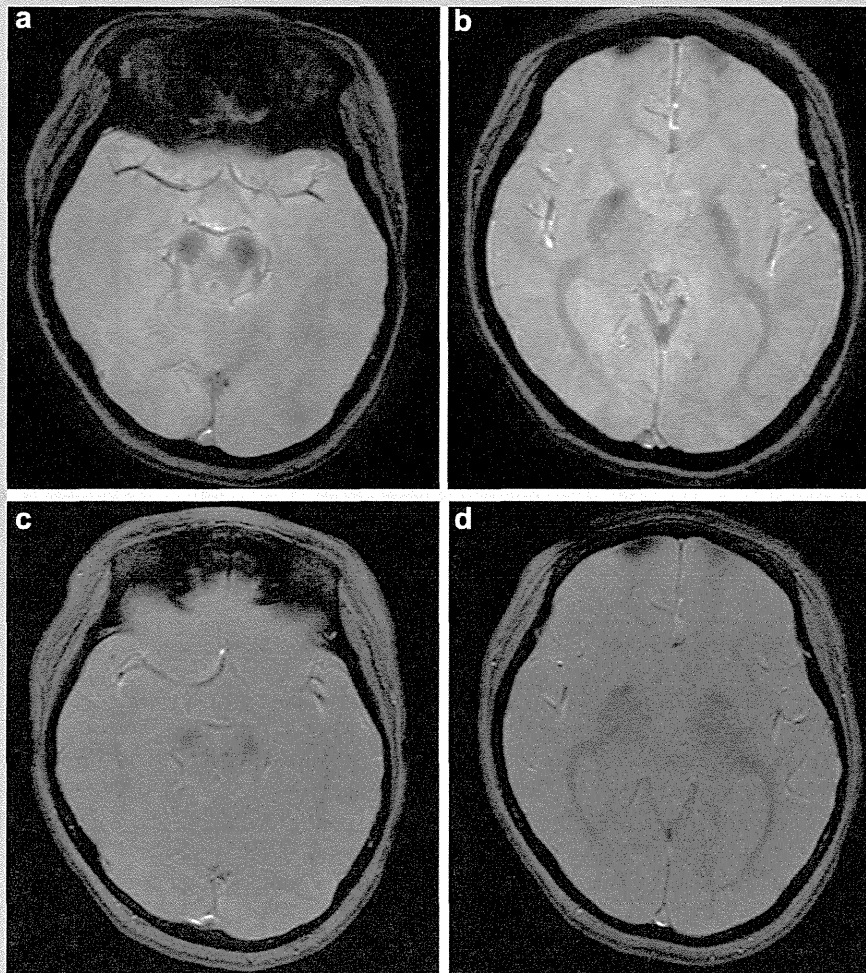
MRI of the patient at 6 years of age. T2¹-weighted [a,b] and SWAN [c,d] axial images of the patient at 6 years of age showed hypointensity in the substantia nigra and the globus pallidus, consistent with iron accumulation.
